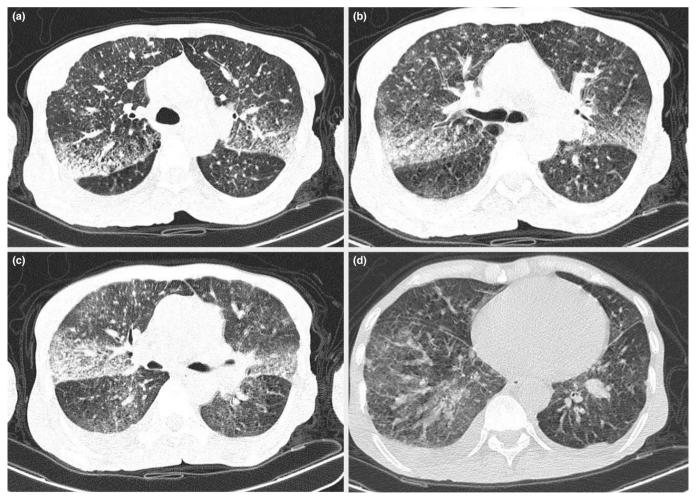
Thorax computed tomography (CT) section taken at the emergency room (ER)
